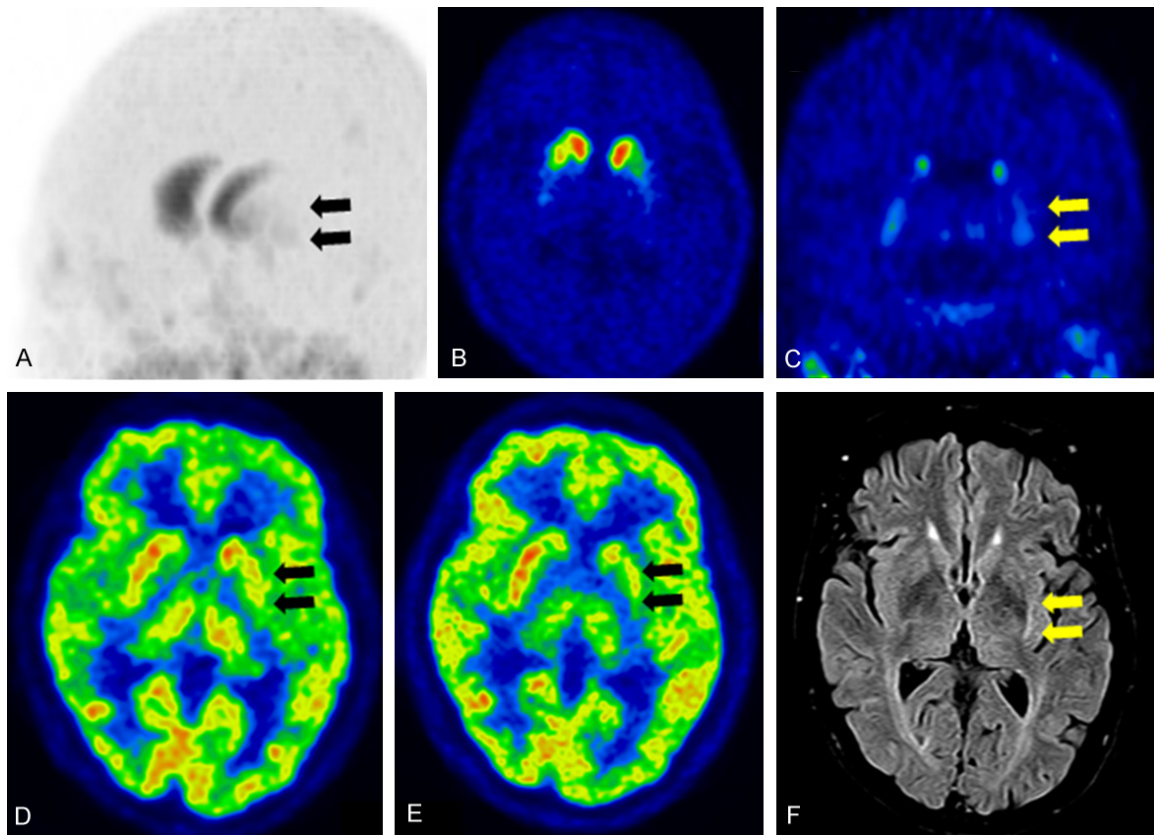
Multiple systemic atrophy with predominant parkinsonism (MSA-P) (A) Maximum intensity projection image of DAT imaging using ^{18}F -FP-CIT showing decreased tracer uptake in the posterior putamen and ventral putamen, and relative preservation of the caudate nucleus. (B) Transaxial DAT image showing decreased uptake of the putamen with the predominant left side, and (C) coronal DAT image showing equally decreased uptake in the dorsal and ventral putamen with loss of the ventrodorsal gradient. (D) Early perfusion image of ^{18}F -FP-CIT and (E) glucose metabolism of ^{18}F -FDG showing decreased perfusion and glucose hypometabolism in the posterior putamen. (F) FLAIR MR image showing atrophic changes in the left putamen and high signal intensity at the rim of the left putamen.
